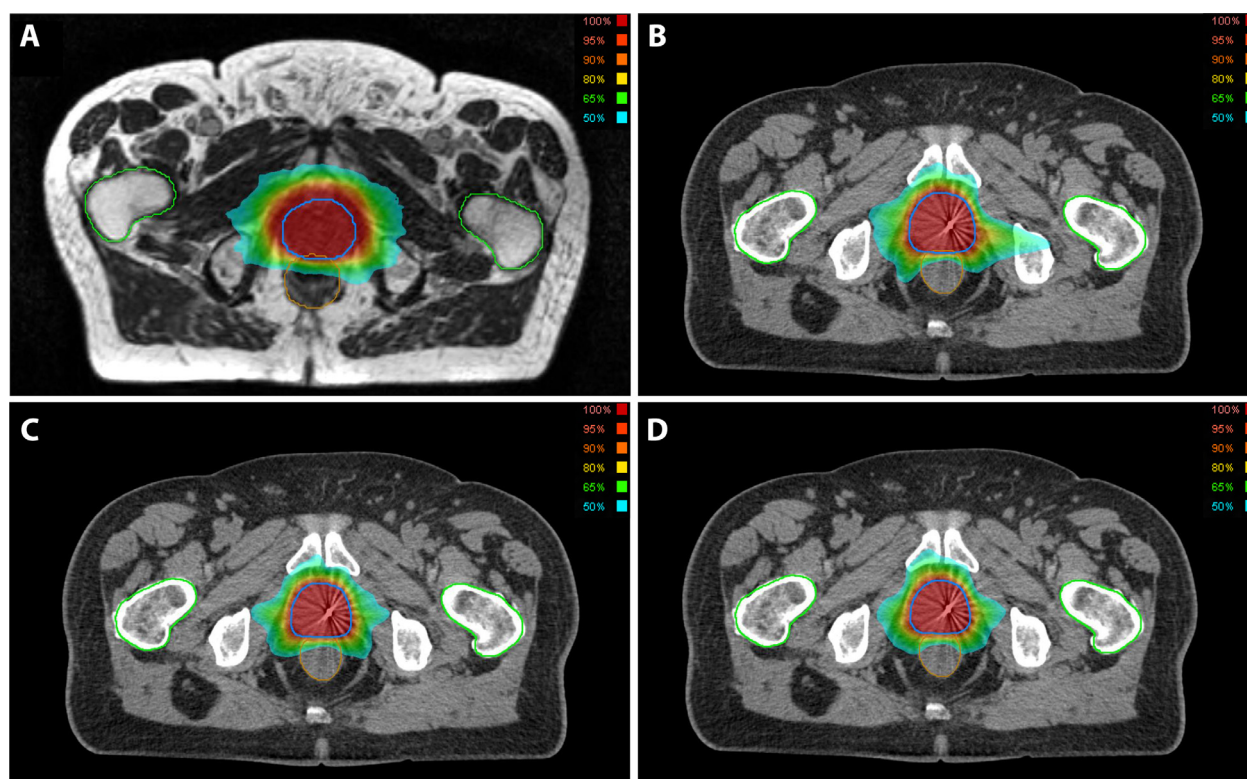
Example radiation therapy plans for patients treated with MRgSBRT (patient 1) or CTgSBRT (patient 2). The 40 Gy planning target volume (PTV) is outlined in blue, the rectum is outlined in brown, and the femoral heads are outlined in green. (A) Axial view of MRgSBRT utilizing a 2-mm PTV margin per MIRAGE (Magnetic resonance imaging-guided versus computed tomography-guided stereotactic body radiotherapy for prostate cancer) protocol for patient 1. (B) Axial view of CTgSBRT utilizing a 4-mm PTV margin per MIRAGE protocol for patient 2. (C) Axial view of CTgSBRT retrospectively replanned utilizing a 3-mm PTV margin for patient 2. (D) Axial view of CTgSBRT retrospectively replanned utilizing a 2-mm PTV margin for patient 2. *Abbreviations:* CTgSBRT = computed tomography guided stereotactic body radiation therapy; MRgSBRT = magnetic resonance imaging guided stereotactic body radiation therapy.
